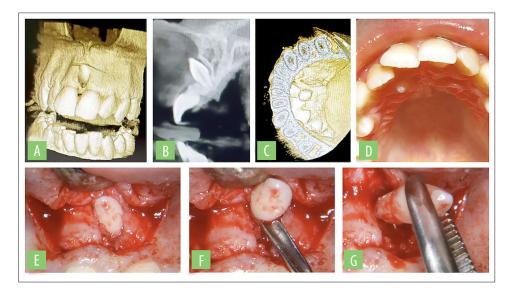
3A, 3B: CBCT showing the buccal mesiodens between the maxillary central incisors. 3C: CBCT showing the palatal mesiodens 3D: Picture of the palatal mesiodens. 3E, 3F, 3G: some pictures during the surgery, extraction of the buccal mesiodens
